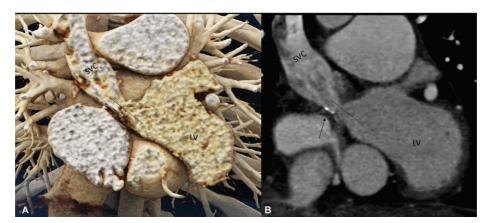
(A) Coronal cinematic volume-rendered computed tomography image showing stenosis (shown by *dotted black line*) of systemic baffle. (B) Coronal computed tomography image showing stenosis of the systemic baffle (shown by a *dotted black line*) and calcification of the baffle (shown by a *black arrow*). LA, left atrium; SVC, superior vena cava.
